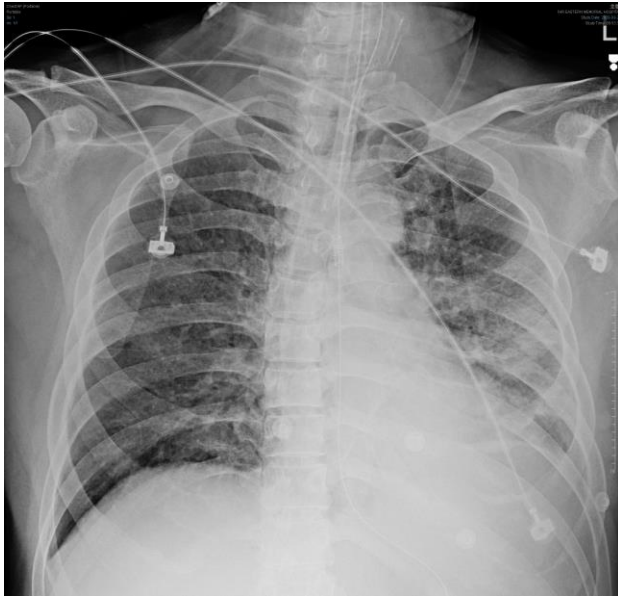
Chest x-ray on the day of ICU admission.
